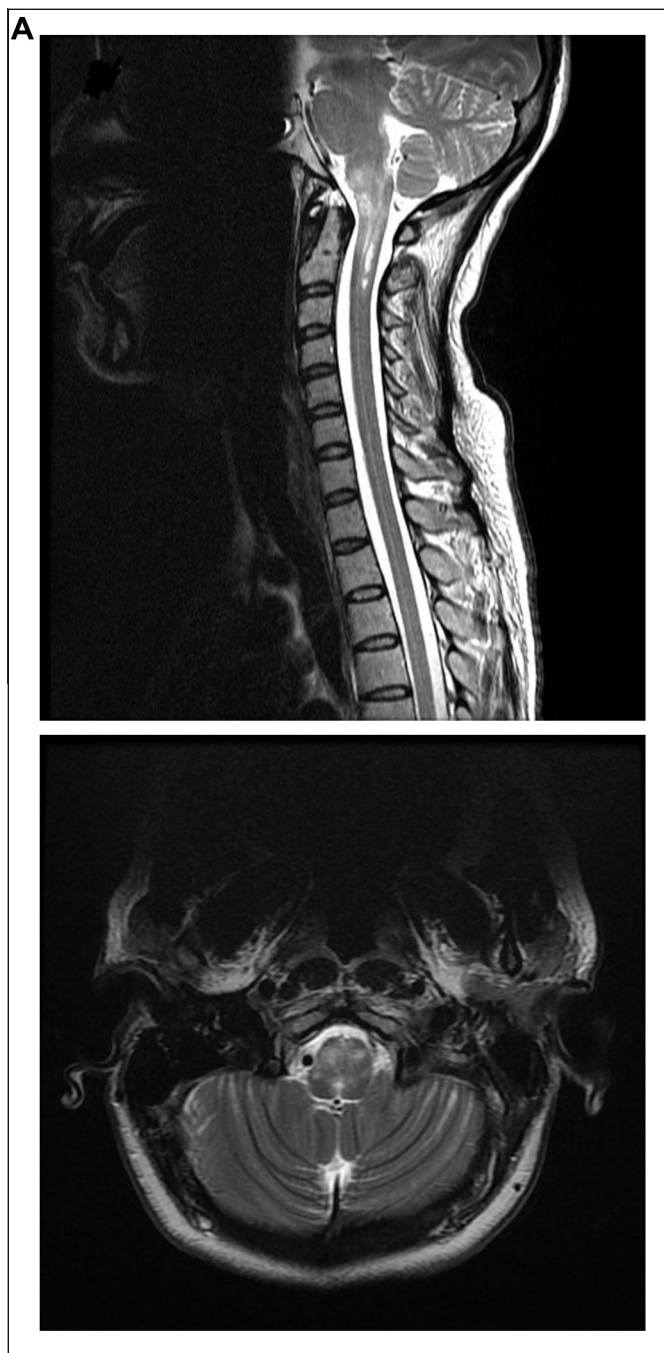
Pre-treatment sagittal and axial T2-weighted MRI of medulla and cervical spine, showing diffuse, ill-defined hyperintense lesion involving the medulla oblongata and the upper cervical cord.
